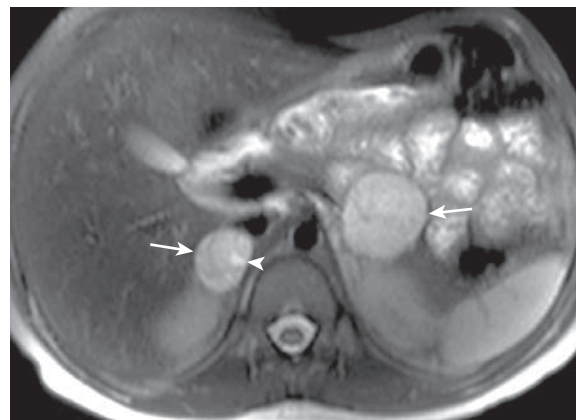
Bilateral pheochromocytoma in an 11-yr-old child with von Hippel-Lindau disease and arterial hypertension. An axial fat-suppressed T2 weighted magnetic resonance image shows bilateral adrenal masses (arrows), larger on the left. The masses are hyperintense with small cystic change on the right medially. (From Navarro OM, Daneman A. *Acquired conditions*. In: Coley B, ed. *Caffey's Pediatric Diagnostic Imaging*, 12th ed. Philadelphia: Elsevier; 2013: Fig. 123.9.)
